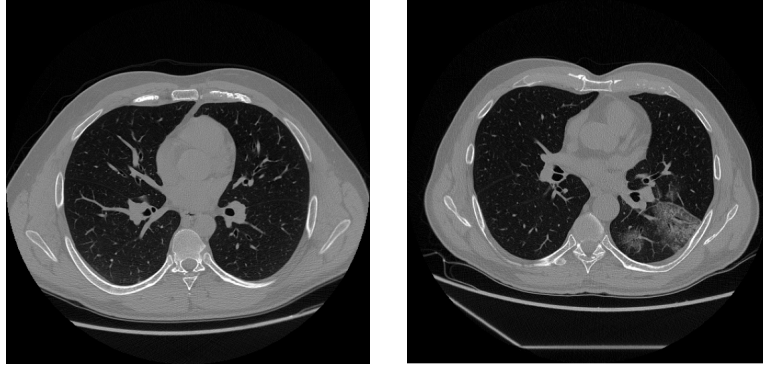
CT scan of thorax for an healthy patient(left) and a COVID-19 affected one(right) in which we can observe a huge amount of GGO in the right lung*
